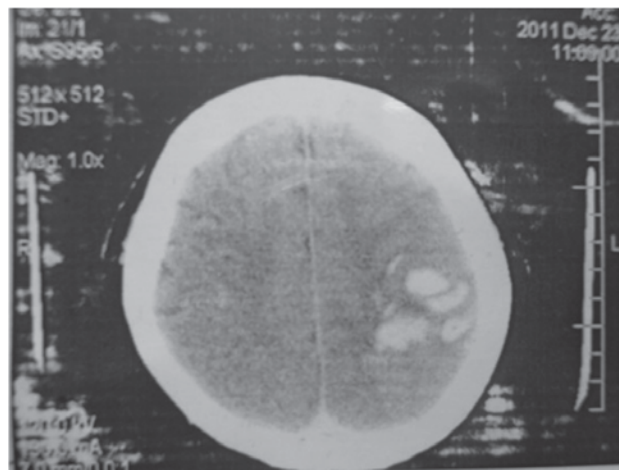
Computed tomography (CT) scan revealing intra cerebral haemorrhage in the left parietal lobe
